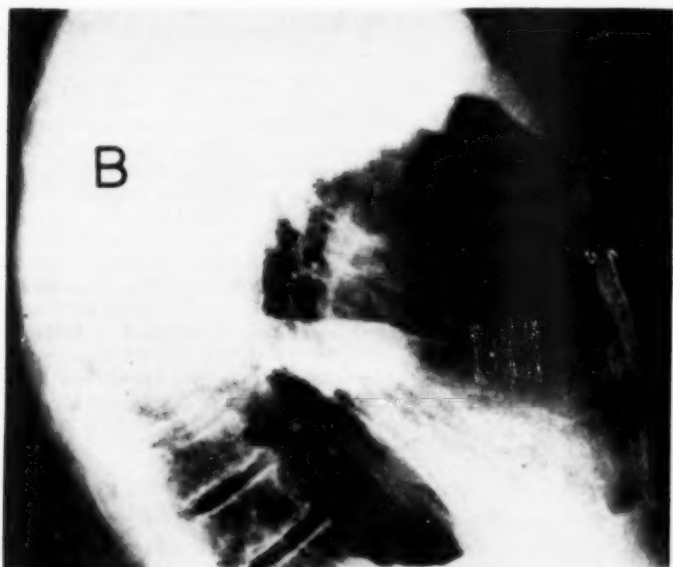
Lateral roentgenogram of patient F. F., May 24, 1951, showing interlobar effusion in the transverse fissure.
